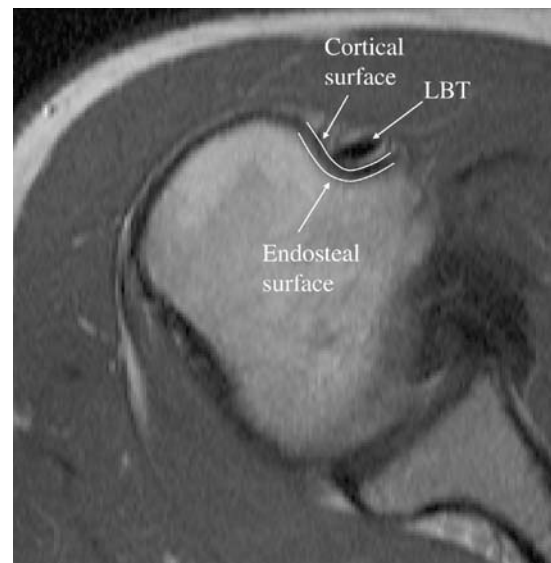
Appearance of bone on T2-weighted MRI. The inner surface where bone meets bone marrow is the endosteal surface. The outer surface where bone meets surrounding tissue is the cortical surface. We must distinguish between these during surface extraction, because the LBT contacts the cortical surface.
